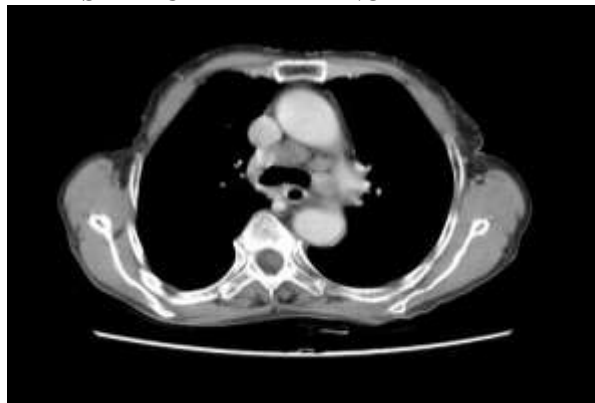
Axial CT of thorax in a 70 years old female showing metastatic lymphadenopathy.
